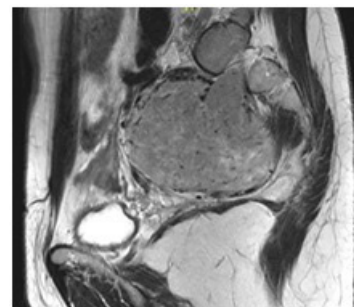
Coronal MRI with the pelvic tumor causing uterine and rectal displacement and extended towards left S1 foraminal.
